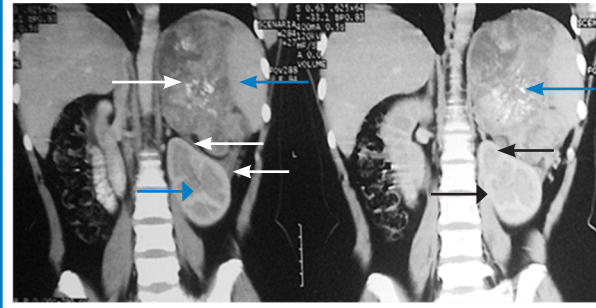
Coronal reconstructed CT images following oral and IV contrast showing a large heterogeneously enhancing mass (black arrows) in the left suprarenal region pushing the left kidney (notched right arrows) downwards and adhering to the renal fascia (blue arrows) and the spleen (red arrows).
